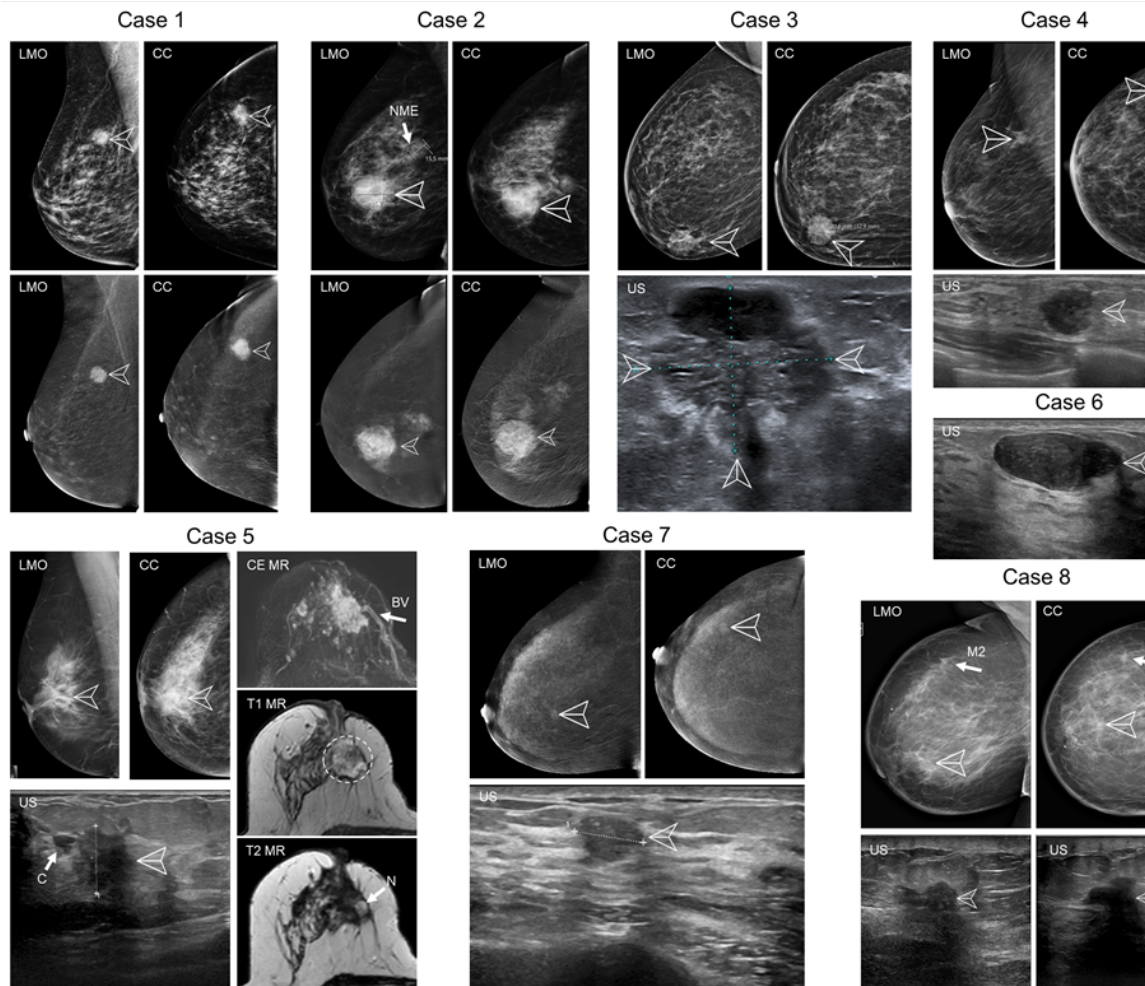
Conventional clinical images of the eight cases presented in the results. Lesions are marked by arrowheads. Case 1: Contrast-enhanced mammography of the right breast showing the enhancing mass with indistinct borders in the upper outer quadrant in lateromedial oblique (LMO) and craniocaudal (CC) views. Case 2: Contrast-enhanced mammography (LMO and CC) of the right breast showing a mainly circumscribed, partially indistinct tumor and adjacent non-mass enhancement (arrow NME) without clear findings in the Low energy (upper) image. Case 3: Mammography (LMO and CC) and a conventional ultrasound (US) image of the tumor containing well circumscribed hypoechoic parts (either cystic or containing more aggressively growing cells) and some spiculated, less hypoechoic infiltrating parts. This example reflects tumor heterogeneity. Case 4: Mammographs (LMO and CC) and a conventional ultrasound image of the microlobulated round tumor. Case 5: Mammographs (LMO and CC), a conventional ultrasound, contrast-enhanced, T1- and unenhanced T2-weighted magnetic resonance (MR) images of the partially necrotic tumor. A large feeding blood vessel subtracted CE-MR, arrow BV) is visible near the lesion in a position matching the observation in the OA image (Fig. 7.5F, arrow 1). Necrosis is visible in the tumor core (T2 image, arrow N) usually reflecting a very fast tumor growth. The ultrasound shows a cyst or a dilated duct near the tumor core (arrow C). Case 6: An ultrasound image of a fibroadenoma. The lesion has a typical appearance: hypoechoic, oval-shaped, with a uniformly distributed texture and smooth borders. Case 7: Contrast-enhanced mammography (LMO and CC) and an ultrasound image of the breast containing the tumor. The 10 mm large lesion is oval to round, with unsharp borders and a disruption of some anatomical structures. Case 8: Mammography (LMO and CC) and ultrasound images of the breast with a recurring inflammatory mamma carcinoma with skin thickening and two masses: arrowheads mark the mass imaged in this study, appearing in the as irregular mass with shadowing features. A secondary mass is marked by arrow M2. Figure reproduced from Kukačka *et al.* "Image processing improvements afford second-generation handheld optoacoustic imaging of breast cancer patients." *Photoacoustics* 26 (2022): 100343.
